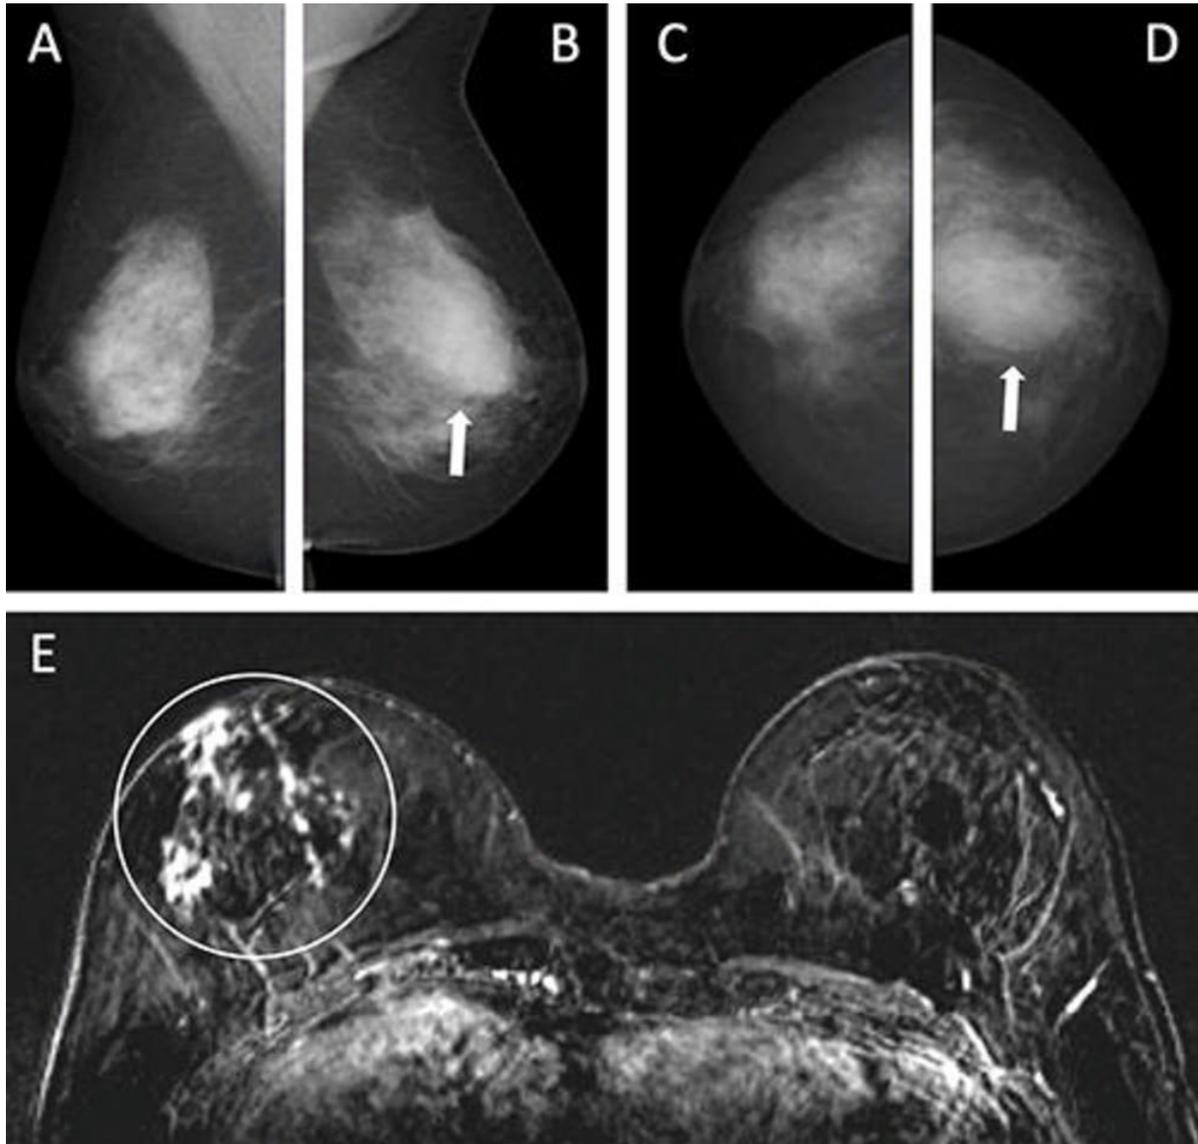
Images in a 55-year-old woman with a family history of breast cancer who underwent combined mammography and MRI screening. (A) Right and (B) left mediolateral oblique and (C) right and (D) left craniocaudal mammograms show a large known cyst in the left breast (arrow in B and D) but was otherwise assessed as being unremarkable. Breast tissue was judged to be extremely dense. (E) Concurrent axial subtraction MRI scan shows a large, diffuse, invasive lobular cancer (circle) in the right breast. The artificial intelligence system provided a case-based cancer suspicion score of 8 on a scale of 0–10, which would have led to selection for MRI screening using both the score 5 and score 8 thresholds, but not the score 9 threshold. [High-res.\(TIF\) version](#)
